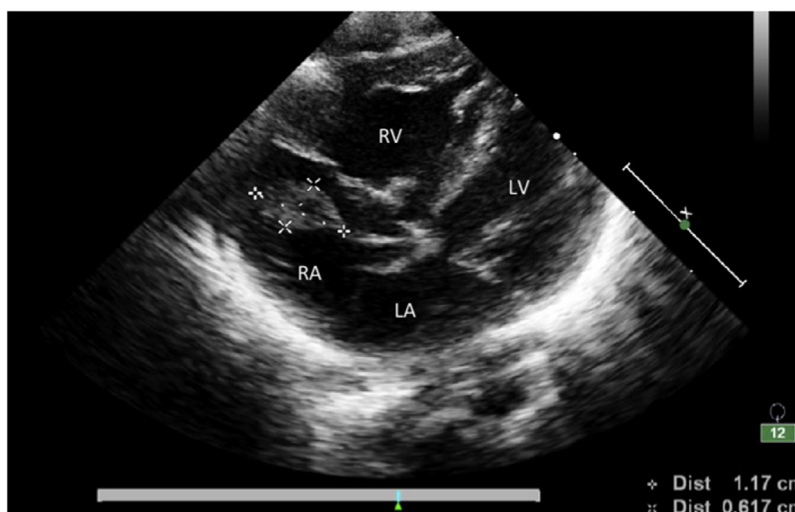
Right atrial myxoma dimension. Echocardiogram shows a mass attached to the interatrial septum causing flow obstruction.
